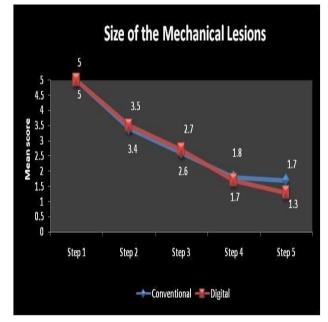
Comparison of Mean scores of Conventional and Digital imaging at various steps in mechanically prepared periapical lesion
